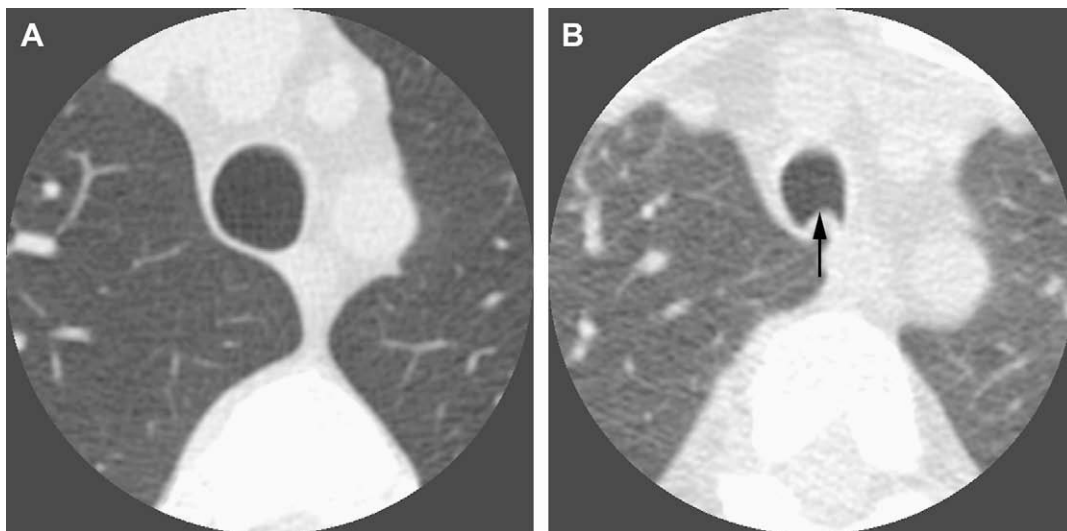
Dynamic tracheal changes in a 45-year-old asymptomatic male volunteer with normal pulmonary function. Axial end-inspiratory CT image above level of aortic arch (A) demonstrates normal oval-shaped tracheal lumen. Axial dynamic-expiratory CT image at same level (B) demonstrates moderate anterior bowing of posterior membranous wall of trachea (arrow). Cross-sectional area of the tracheal lumen decreased by 51% during expiration, slightly exceeding the diagnostic criterion for TM.
